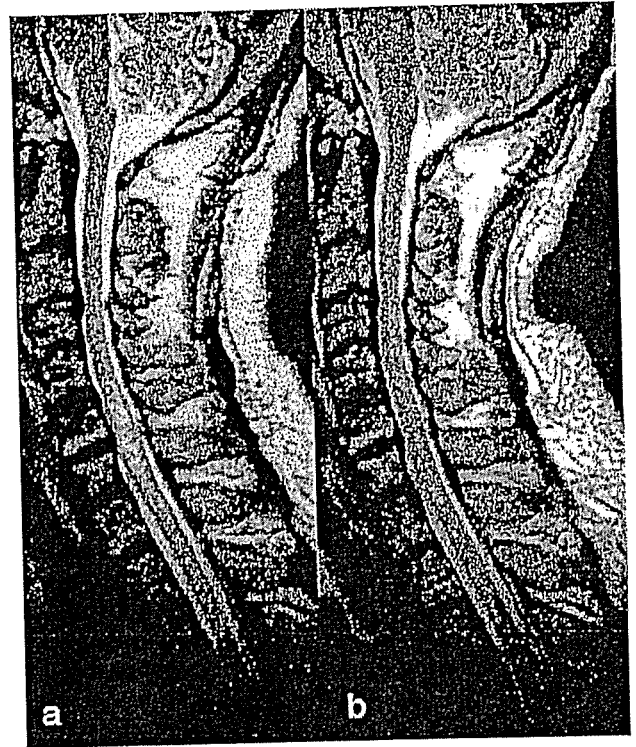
MRI before (a) and after (b) treatment (patient 3). (a) Sagittal T2WI demonstrates high signal intensity and swelling of the spinal cord from C2 to T3. (b) Sagittal T2WI shows remarkable decrease in high signal intensity.
